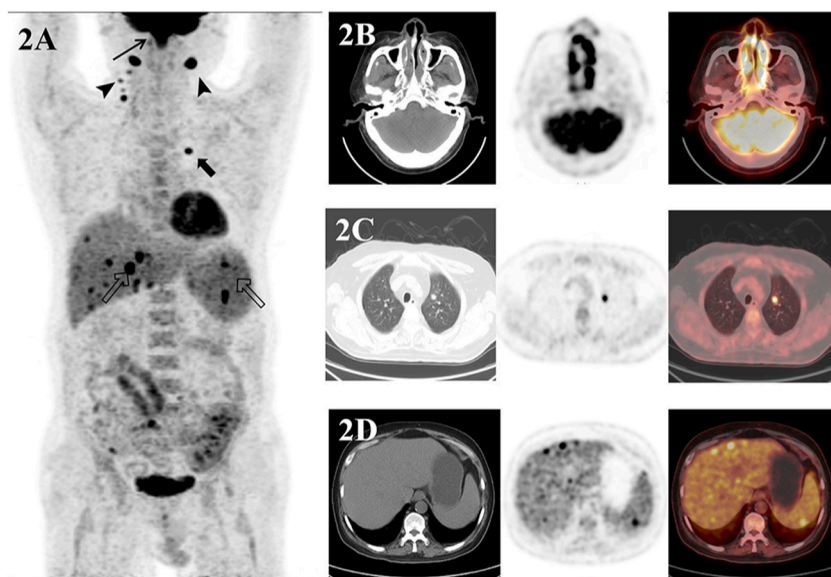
A 50-year-old man with recently diagnosed nasal-type NK/T-cell lymphoma underwent ^{18}F -FDG PET/CT scan (A–D) for initial staging. Maximum-intensity-projection image (A) shows hypermetabolic lesions in both ethmoid sinus (thin arrow), both cervical lymphatic chains (arrowhead), left upper lung (thick arrow), liver, and spleen. Transaxial images of ^{18}F -FDG PET/CT scan show ^{18}F -FDG-avid mass in both ethmoid sinus (B). ^{18}F -FDG PET/CT scan shows intense ^{18}F -FDG uptake in left upper lung and multiple ^{18}F -FDG uptake in the liver and spleen (CT showed no lesions), suggesting malignancy (C–D). Finally, after PET/CT scan is done, staging is changed from II to IV.
